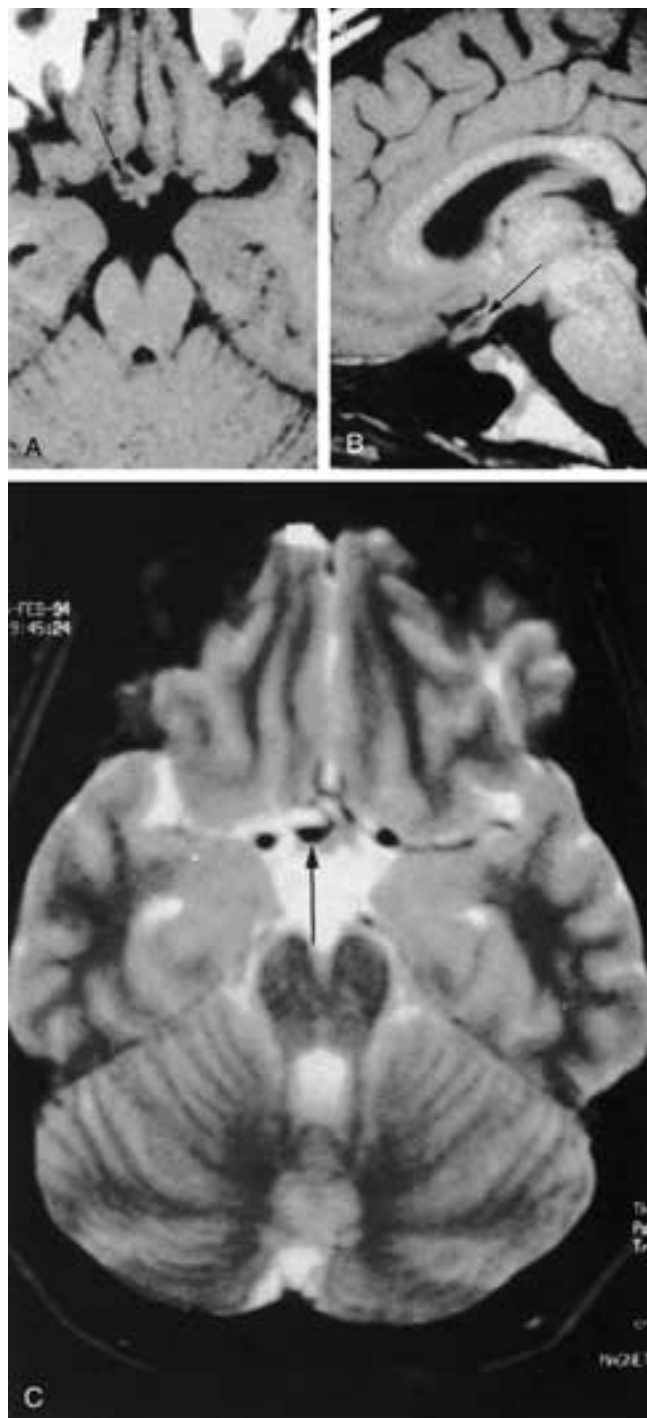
Occult vascular malformation of the right optic nerve in an 18-year-old female with monocular visual loss in the right eye for more than 1 year. The patient was referred with the diagnosis of right optic glioma. A and B, Axial and sagittal T1-weighted images without gadolinium enhancement show a hypointense, cystic expansion (arrow) of the intracranial portion of the optic nerve. C, Axial T2-weighted image shows hypointense blood (arrow), dependent within the cyst, the supernatant within the cyst being hyperintense. The findings are consistent with an occult vascular malformation. The same findings were present 1 year before this examination.
